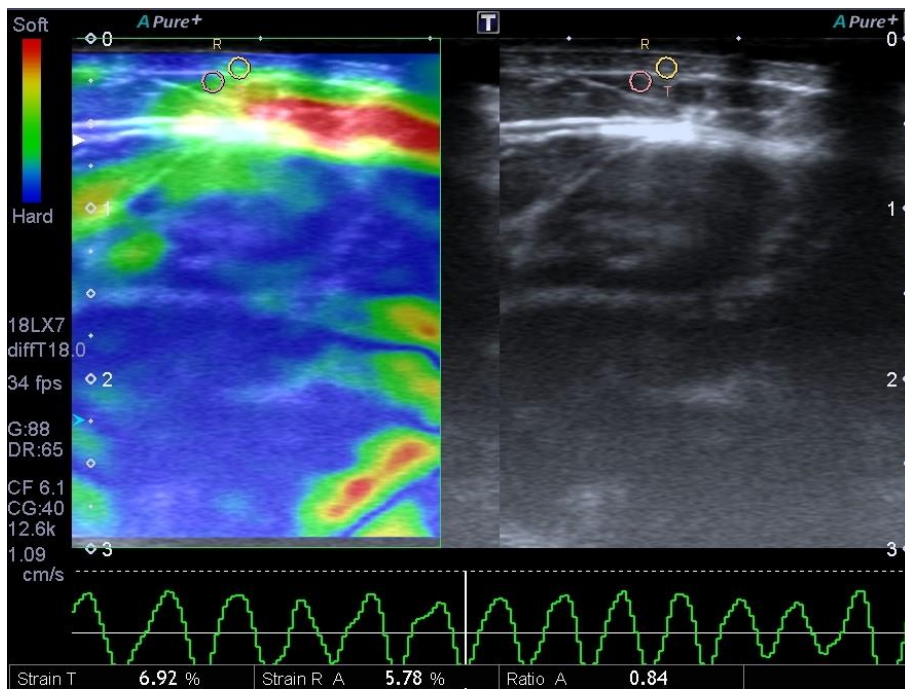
An ultrasound elastography image showing dermal psoriasis. The screen is divided into three parts: right side is gray scale USG image, left side is color coded USG elastography image, and the bottom side is the sinusoidal wave of compression and decompression. The circles indicate the ROIs. Measurements were applied adjusting the ROI to the psoriasis lesions and adjacent muscles.
